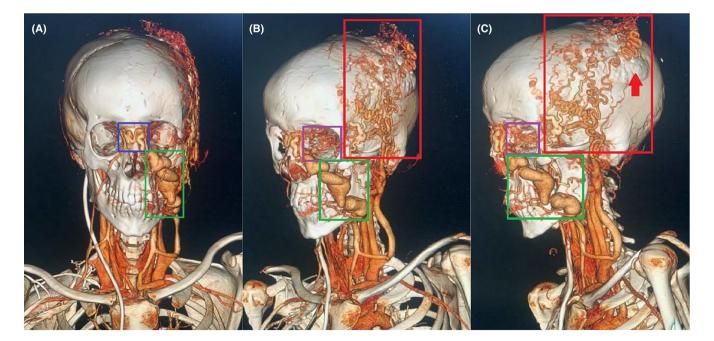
CT cerebral angiography (A–C) demonstrates AVM involving the external nose (blue box), the left orbit (purple box), the maxillary and mandibular region (green box) and the left temporoparietal region (red box) with hyperostosis of the underlying parietal skull bone (red arrow).
